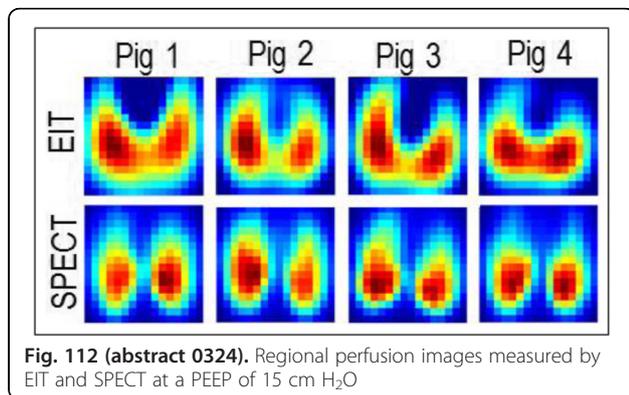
(abstract 0324). Regional perfusion images measured by EIT and SPECT at a PEEP of 15 cm H₂O
